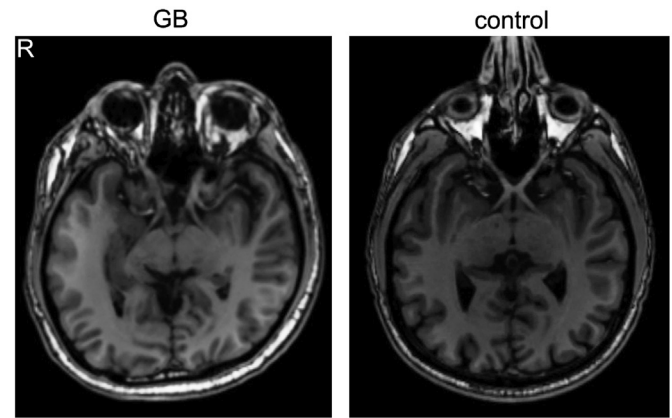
Structural T1-weighted MRI scan shows the optic chiasm in a control subject but not in GB.
